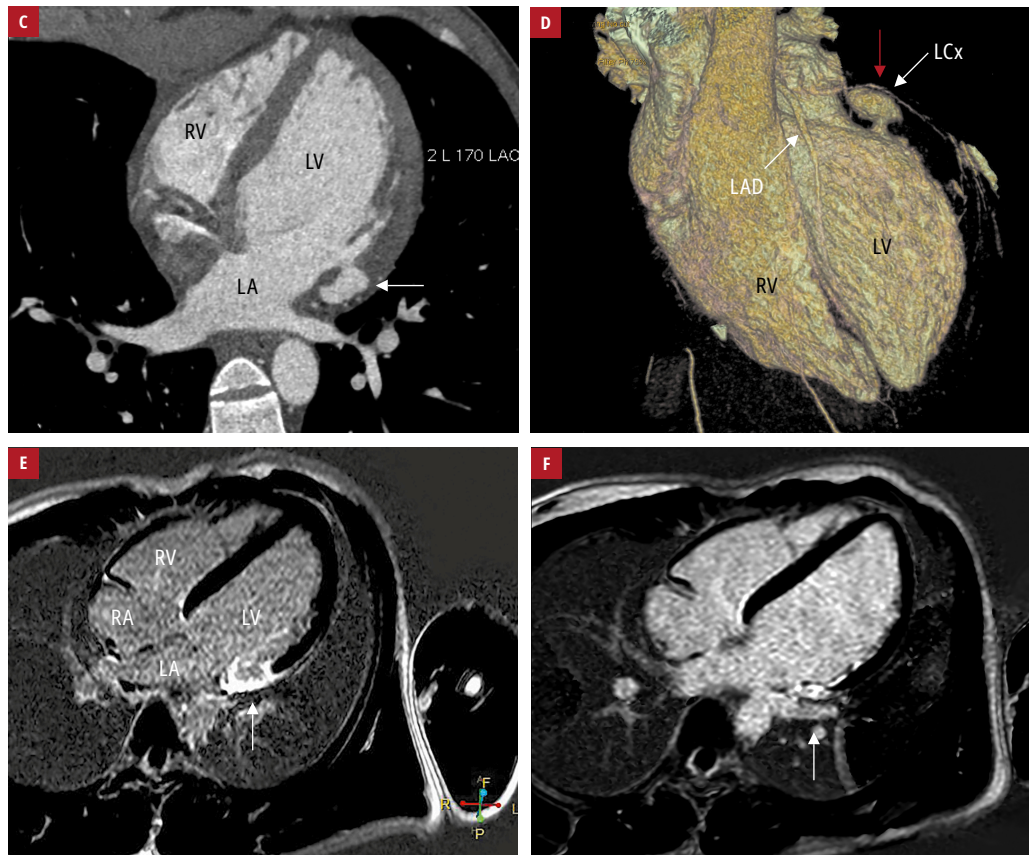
Imaging studies of subepicardial aneurysm: C – cardiac computed tomography showing the aneurysm in the basal lateral wall (arrow); D – cardiac computed tomography (3-dimensional reconstruction) demonstrating left circumflex artery displacement (red arrow); E – initial cardiac magnetic resonance imaging: a transmural scar covering the aneurysm (arrow); F – aneurysm regression (arrow) on follow-up cardiac magnetic resonance imaging
